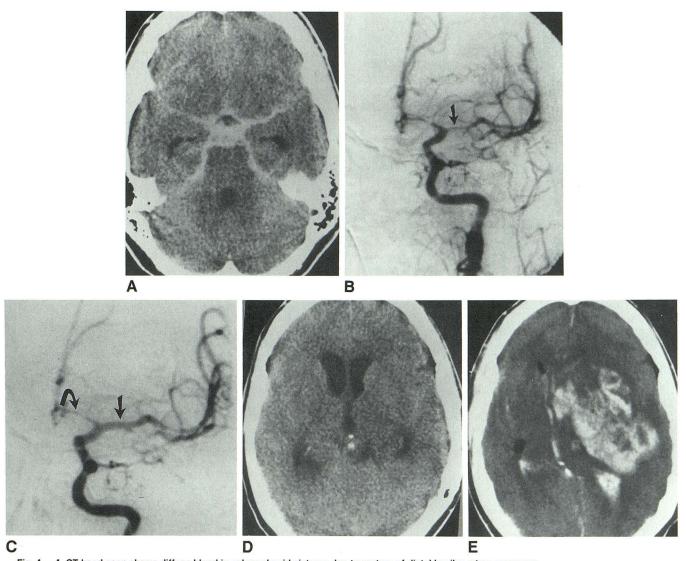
A, CT head scan shows diffuse blood in subarachnoid cisterns due to rupture of distal basilar artery aneurysm.
